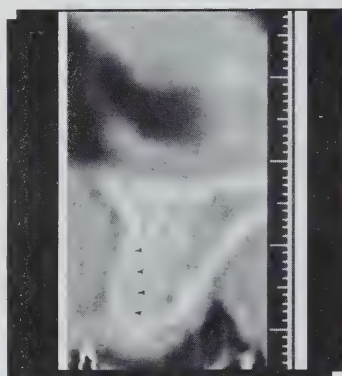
Computed tomography shows new bone resulting from guided bone regeneration. Arrows show the original cortical plate.
